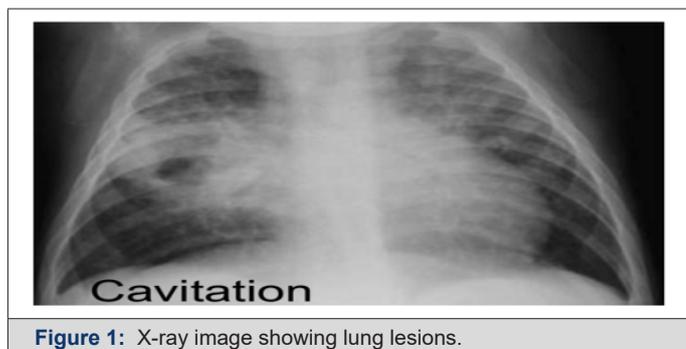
X-ray image showing lung lesions.
